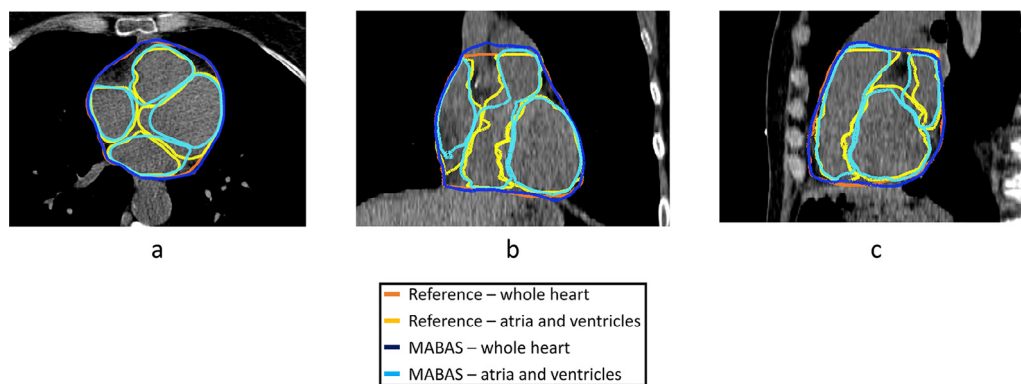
Different views (a: transversal, b: coronal, c: sagittal) of the agreement of MABAS (DIBH10) generated contours and reference contours for a DIBH CT- scan. Abbreviations: MABAS = multi-atlas based automatic segmentation.
